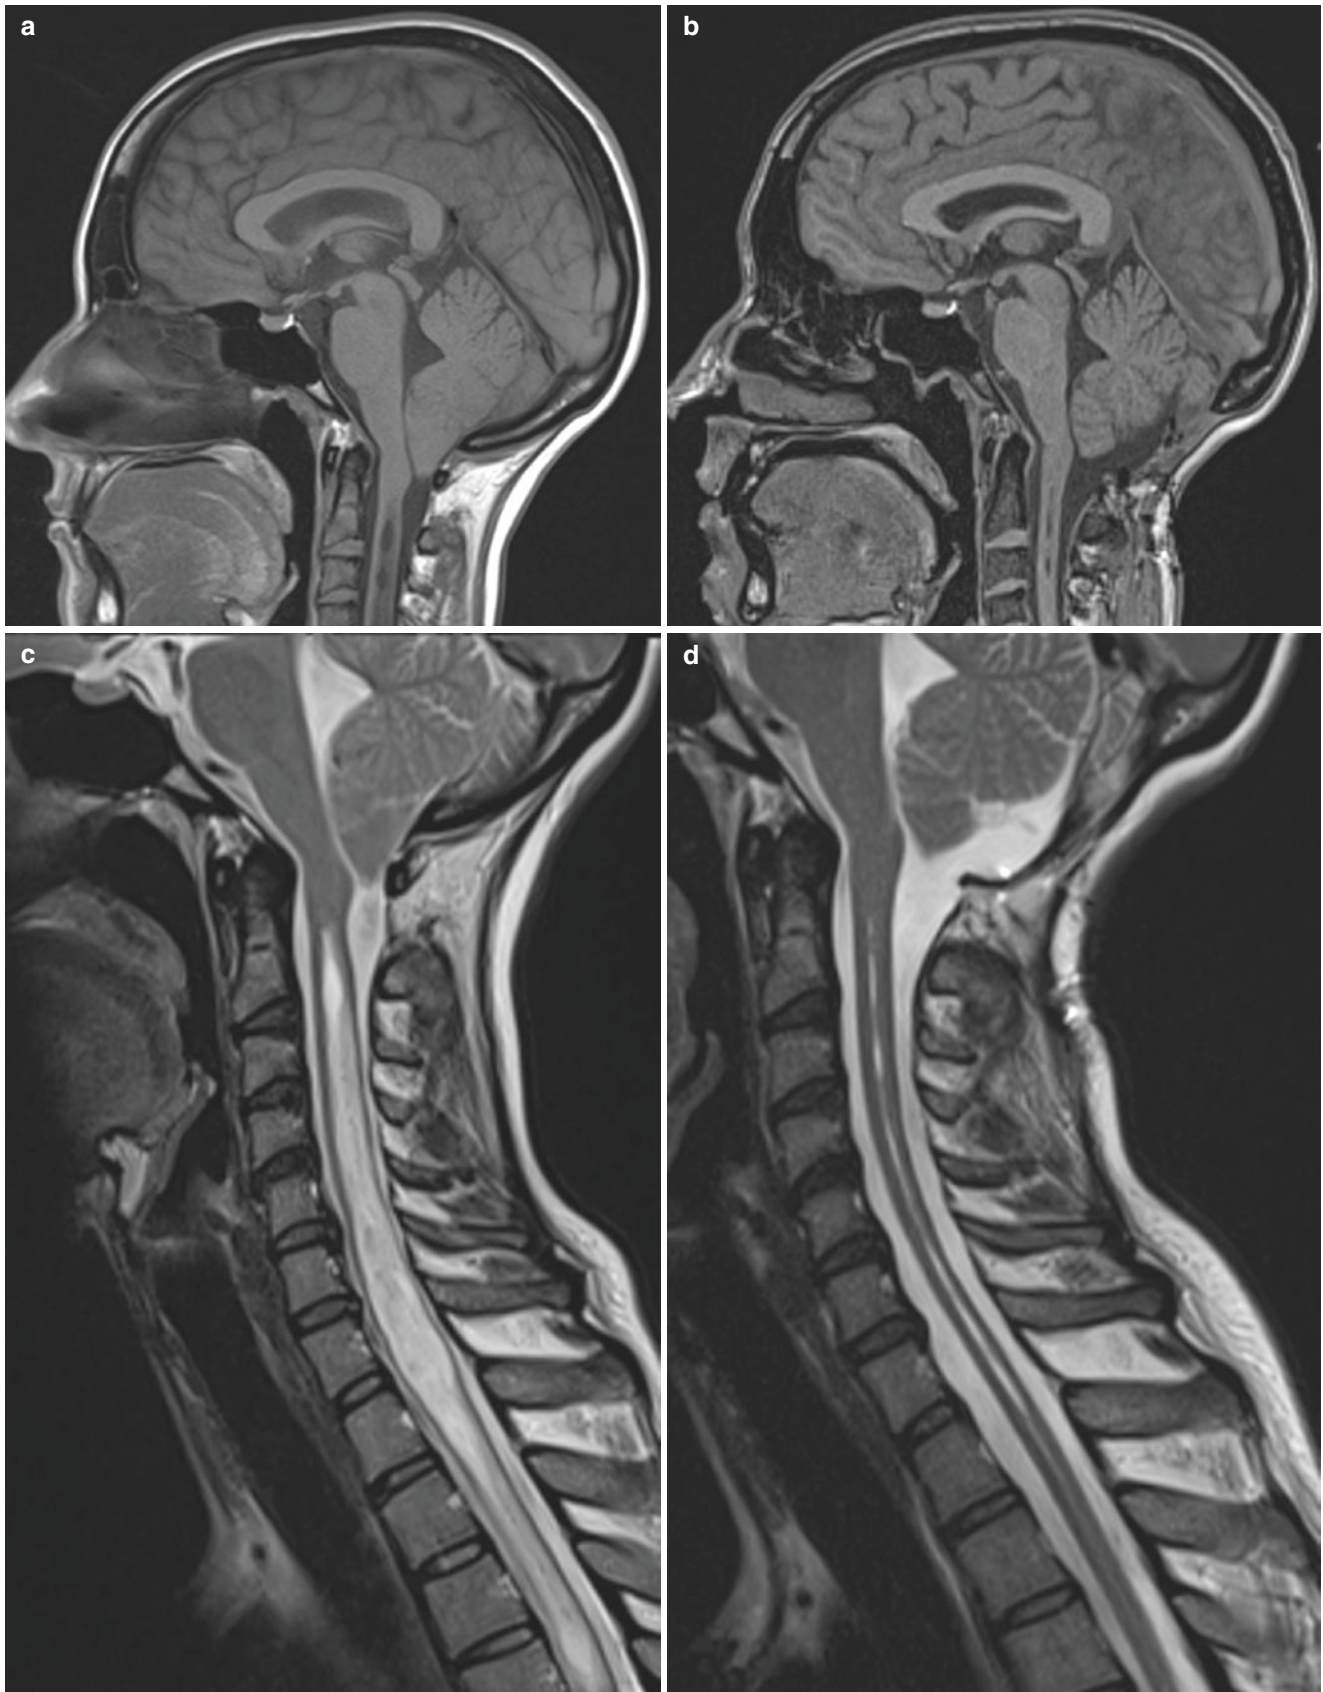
Indications for surgery: the preoperative MRI scans show a CM1 (T1-weighted sagittal scan) in (a) with associated cervico-dorsal syringomyelia (T2-weighted sagittal scans) in (c); the 3-months after
